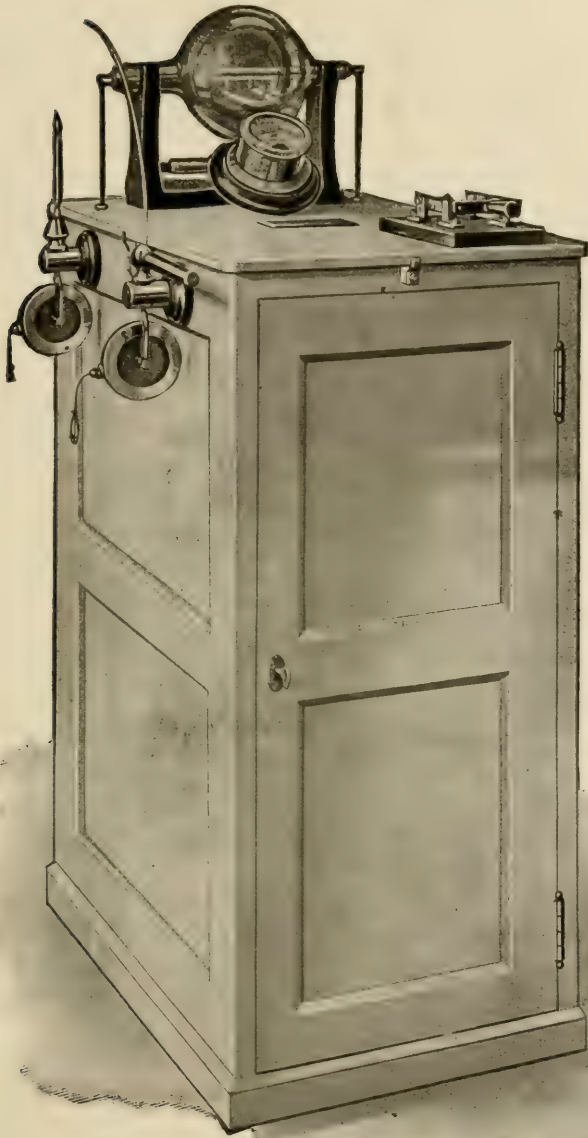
Special dental X-ray machine. Induction coil type. Size: 15 inches wide, 23 inches deep, 36 inches high.
